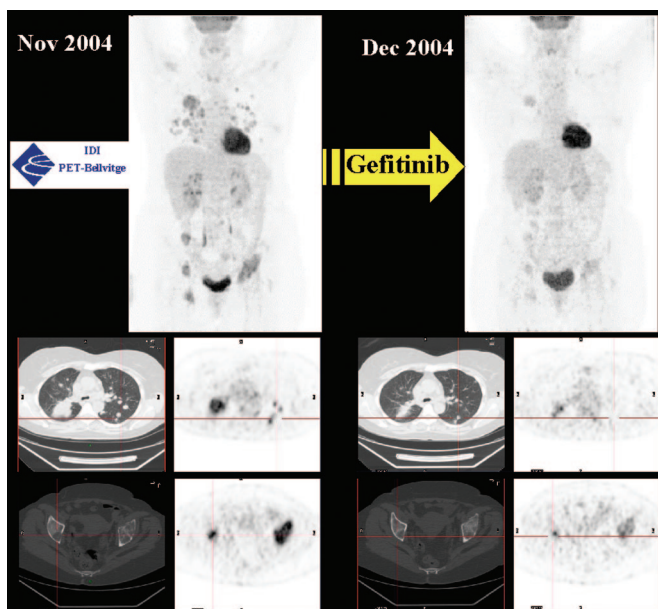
This is a baseline positron emission tomography/computed tomography scan of a 51 year-old woman diagnosed with non-small-cell lung cancer showing a mass in the right lung, lymph nodes adenopathies, and multiple pulmonary and bone metastases. After only 1 month of treatment with gefitinib, the positron emission tomography/computed tomography scan revealed an important metabolic response.
